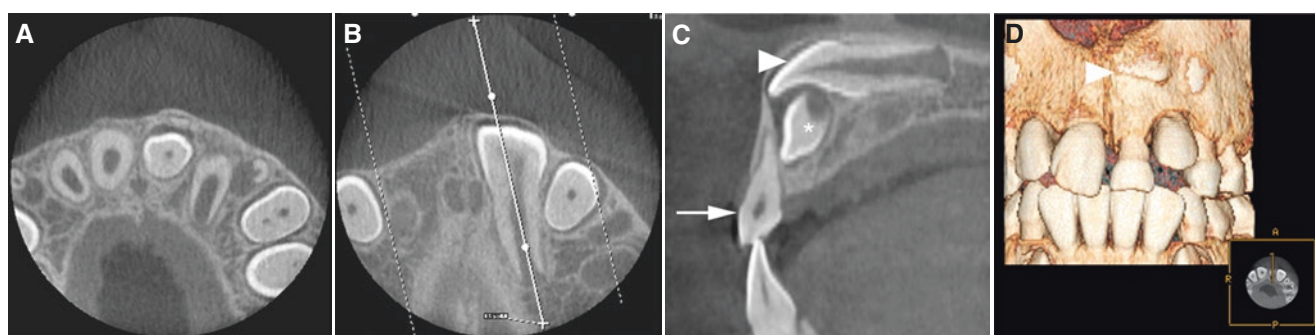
Supernumerary tooth (mesiodens), maxilla; asymptomatic 8-year-old female. (A) Axial, (B) axial (with cursor line), (C) oblique sagittal, and (D) 3D CBCT images show mesiodens (asterisk) palatally
